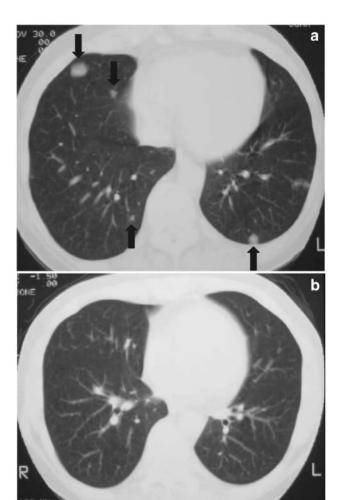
A 56-year-old man with multiple lung metastases of clear cell sarcoma (a, black arrows) showed complete disappearance of the tumor on CT images after five courses of caffeine-potentiated chemotherapy (b).
